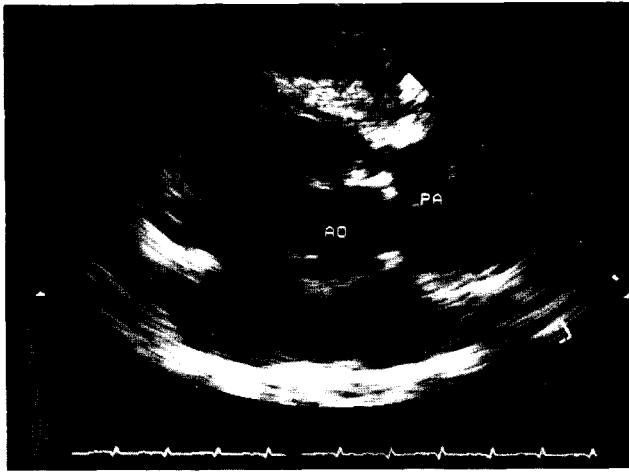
(Case 1.) Postoperative echocardiogram (short axis view at the the great artery level) showing that the aorta is located in the right side of the main pulmonary artery.
